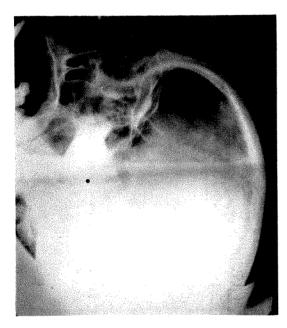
Case 1. Lateral view with roentgen beam horizontal. Made immediately after death. The large collection of air beneath the frontal bone is well seen. The anterior cerebrum is compressed. There is a fluid line passing through the sella turcica. This was the condition found on the portable examination the day after admission.
